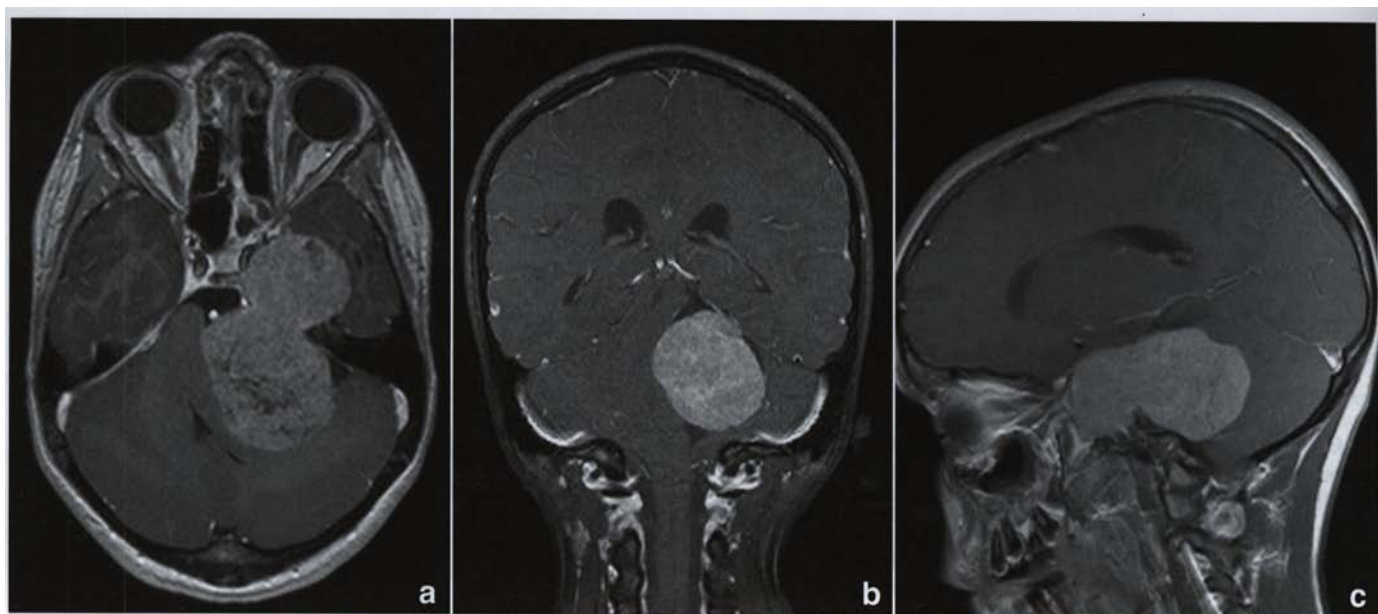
Contrast enhanced axial CT brain of an enhancing dumbbell shaped tumour involving the middle and posterior fossae.
